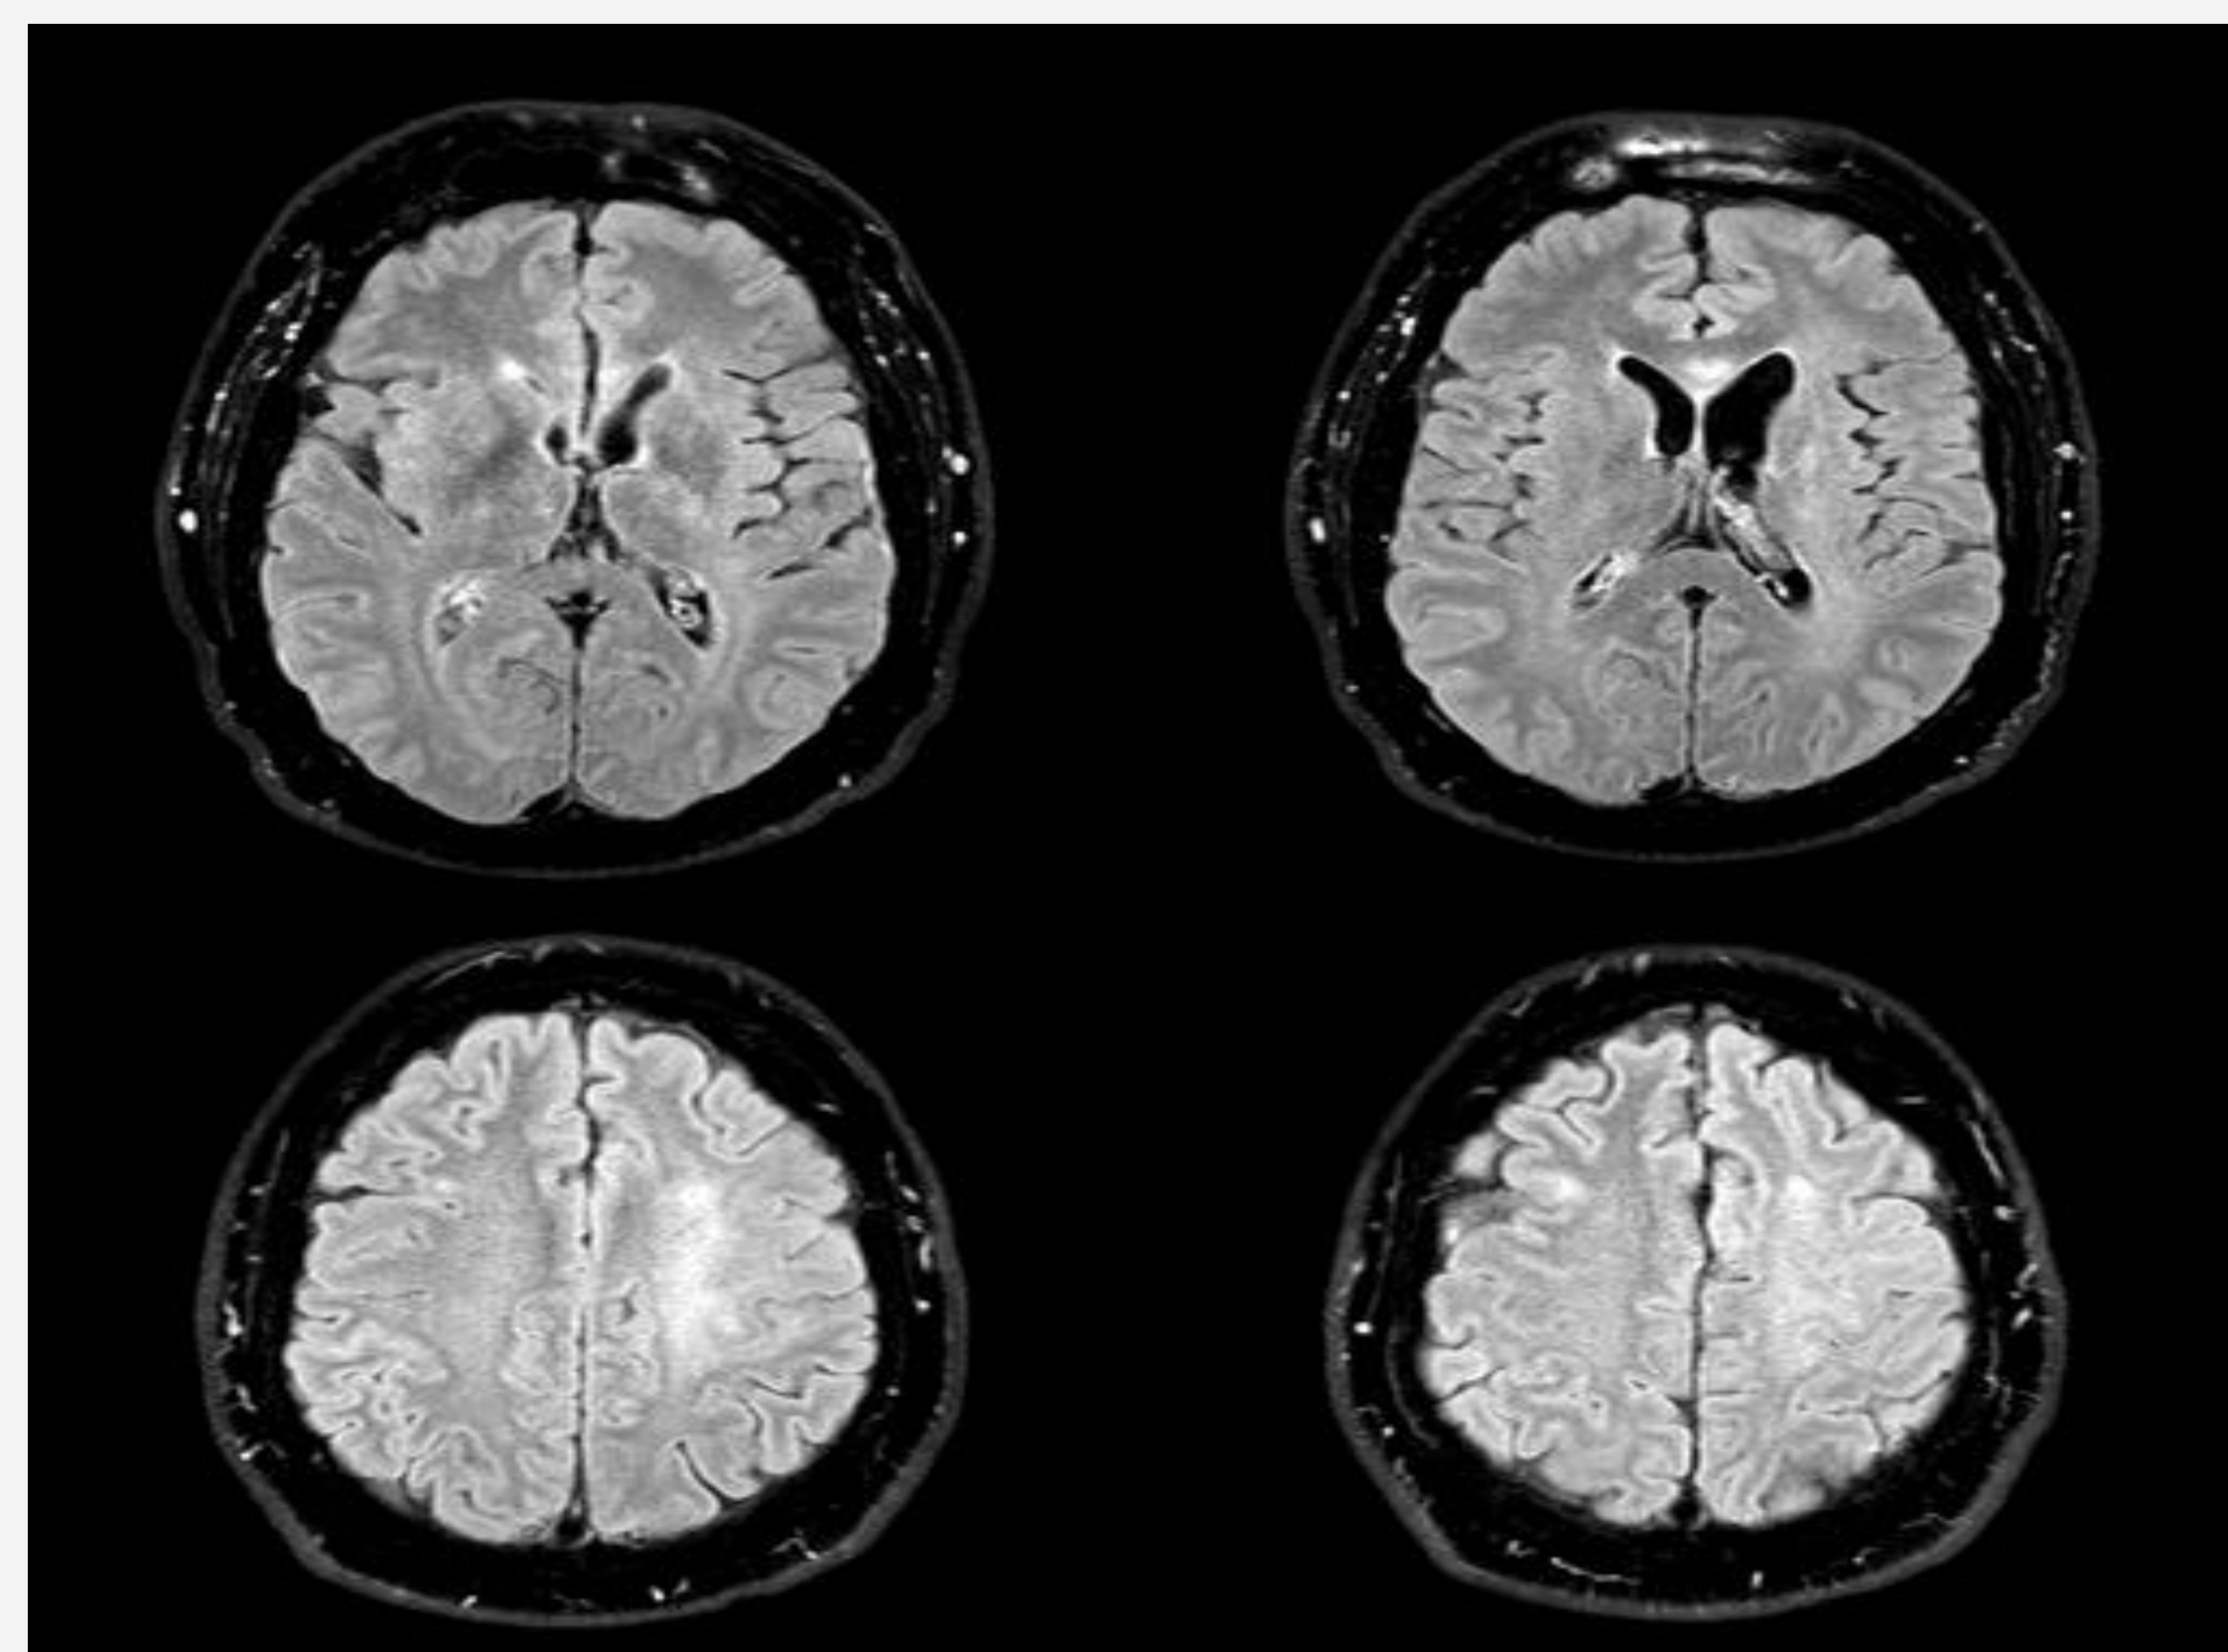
FLAIR-weighted MRI images show hyperintense lesions in the right thalamus and cortico-spinal tract, and in the corpus callosum.
